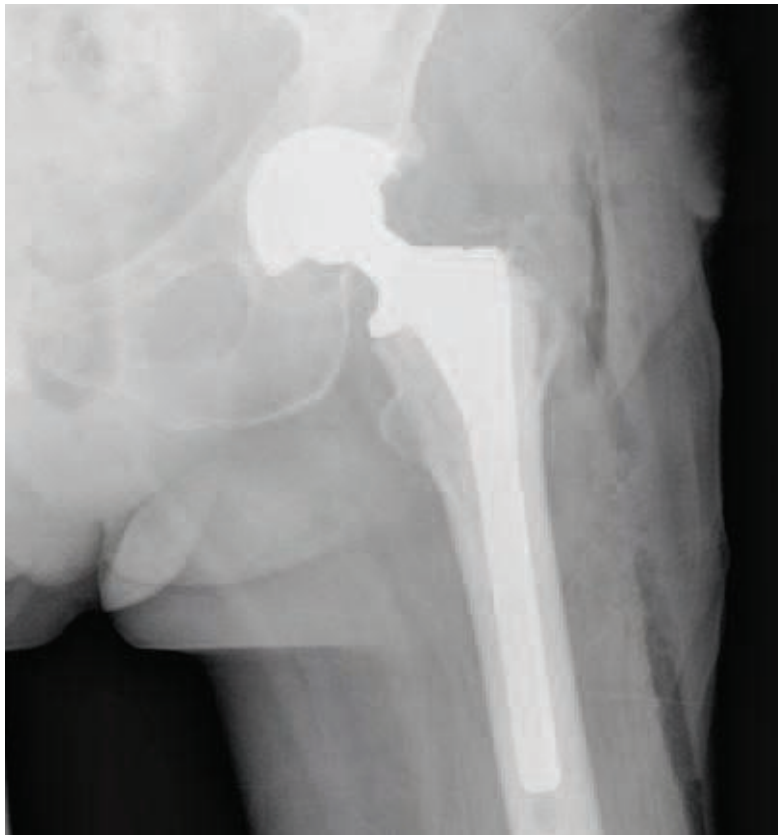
X-ray of patient's left hip following total hip arthroplasty.
